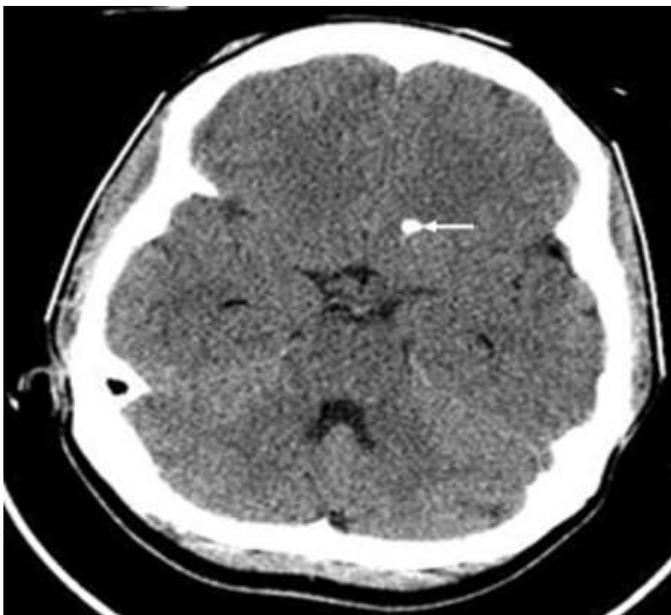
Axial CT at the level of the fourth ventricle showing a calcified cortical tuber in the left frontal lobe (arrow).
